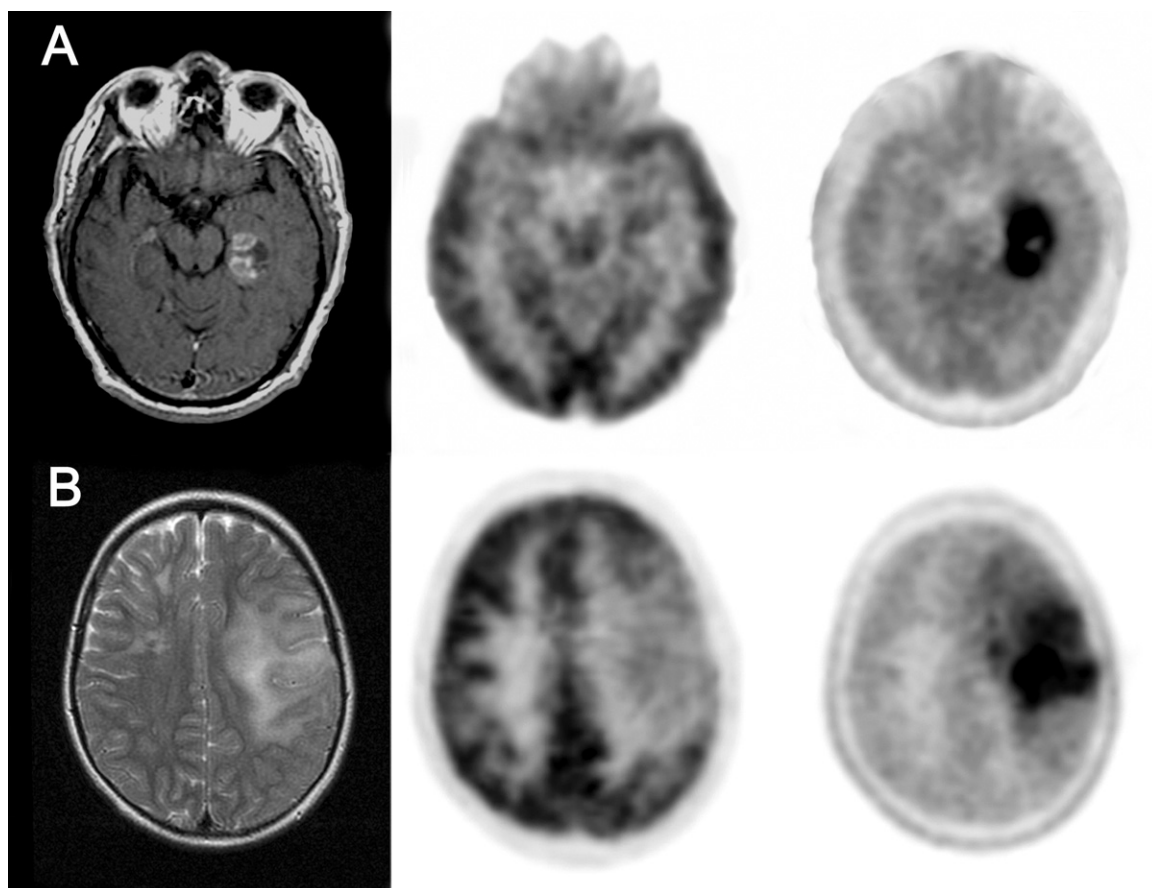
MRI, FDG-PET, and FDOPA-PET of newly diagnosed tumors. (A) Glioblastoma. (B) Grade II oligodendroglioma. (Reprinted by permission of the Society of Nuclear Medicine from Chen et al.⁷²)
